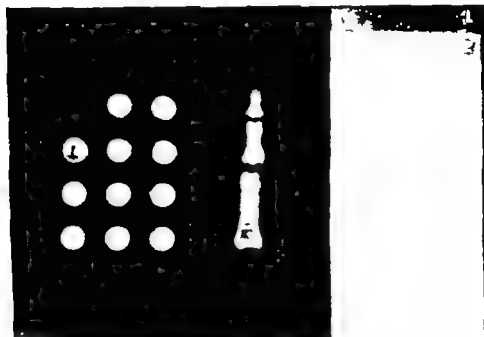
(Courtesy of Reich, S. B., et al: *Am. J. Roentgenol.* 79 705-708 April, 1958.)
